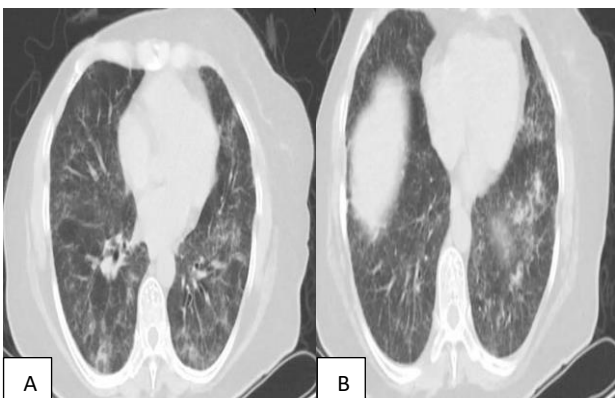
(A and B): Chest CT: ground-glass opacities in the bilateral lower lobes (axial view).
